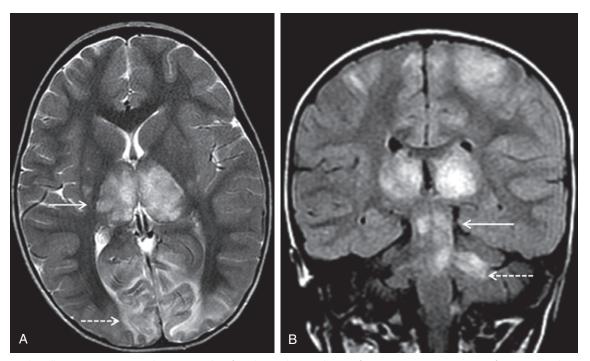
Previously well patient presenting with seizures and profound mental status change after an upper respiratory tract infection. A, Axial T₂ MR image at the level of the basal ganglia delineates marked swelling and hyperintensity in the thalami *(solid arrow)* and posterior cortex/occipital lobes *(dashed arrow)*. B, Coronal T₂ image delineates additional involvement of the brainstem *(solid arrow)* and the cerebellum *(dashed arrow)*. Other sequences also demonstrated restricted diffusion and petechial hemorrhage. The constellation and distribution of findings is most suggestive of acute necrotizing encephalopathy of childhood.
